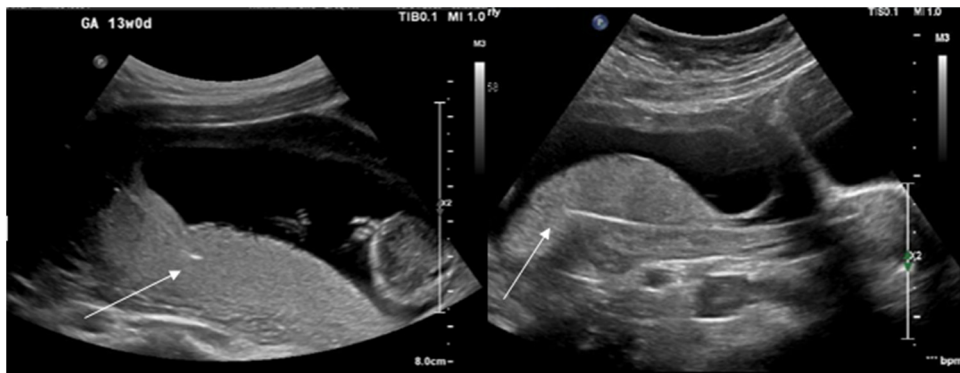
Sonographic examples of a transabdominal chorionic villus sampling (CVS) on the left and transcervical CVS on the right. The arrow points to the placement of the needle/catheter placement into the posterior placenta.
